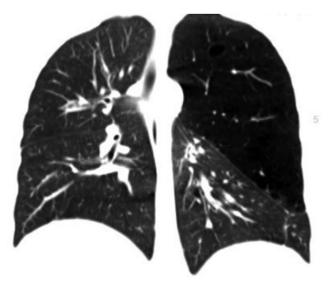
Congenital lobar empysema-thorax computed tomography image.
